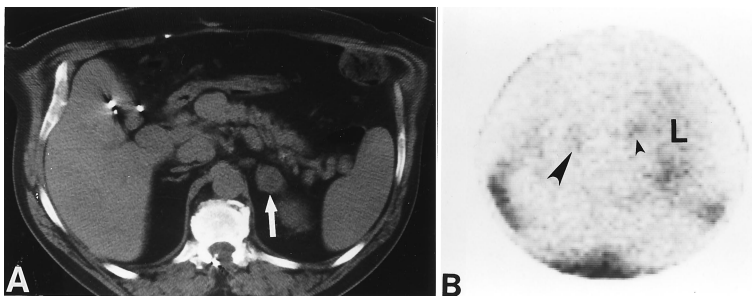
CT examination performed for abdominal pain disclosed a 2 cm in diameter left adrenal mass that yielded a discordant NP59 image pattern. A. CT scan without contrast demonstrates the left adrenal mass (white arrow). B. Posterior abdominal NP59 scintiscan at 5 days after radiotracer injection demonstrates normal uptake in the liver (L) and decreased uptake in the left adrenal gland (large arrowhead) compared to that of the normal right adrenal gland (small arrowhead). The remaining peripheral foci depict normal gastrointestinal radiotracer activity. Subsequent CT-guided fine-needle biopsy demonstrated leukemic infiltration of the left adrenal gland.
